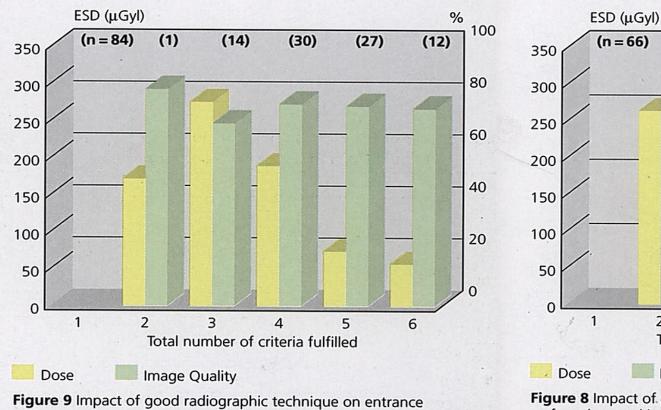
Impact of good radiographic technique on entrance surface dose and image quality: Chest AP/PA examination for 10 year old child; n = number of X-ray departments
